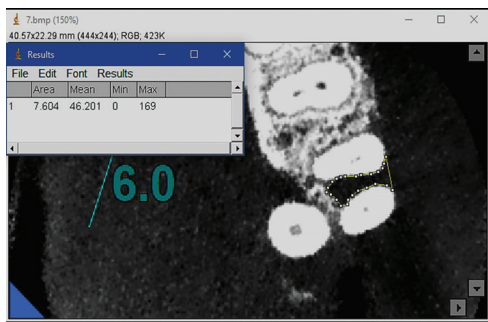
Using ImageJ program to analyze the cross-sectional area of the CBCT image series in the axial plane of sample no. 1’s defect.
